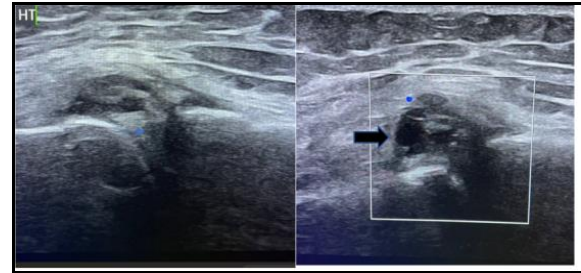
Ultrasound findings: A well-defined small cystic lesion (black arrow) measuring about 6x3 mm is seen lying above the anterior horn lateral meniscus with posterior acoustic enhancement, the lateral meniscus itself showing a horizontal cleft like hypoechoic lesion extending through anterior horn reaching the femoral articular surface (blue arrow). Findings suggestive of horizontal tear with overlying Parameniscal cyst. MRI:
